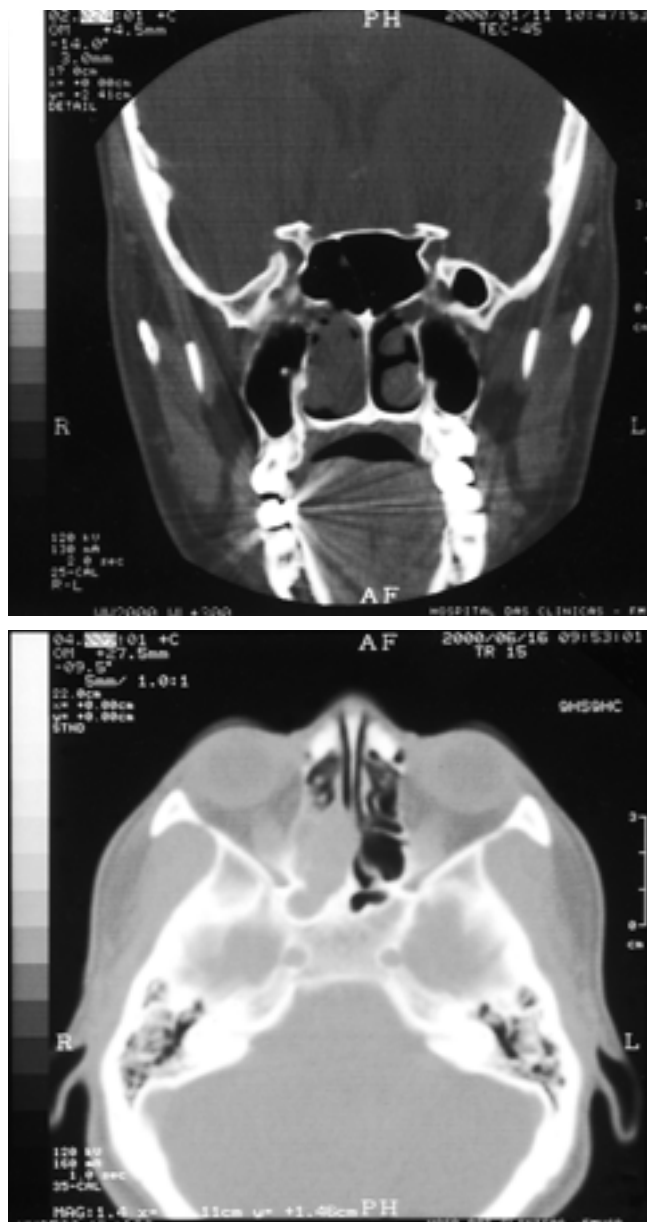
(a) Coronal CT scan, documenting polyp insertion in anterior wall of the right sphenoidal sinus. (b) Axial CT image confirming widening of the ostium of the right sphenoidal sinus and its involvement by the polyp.
